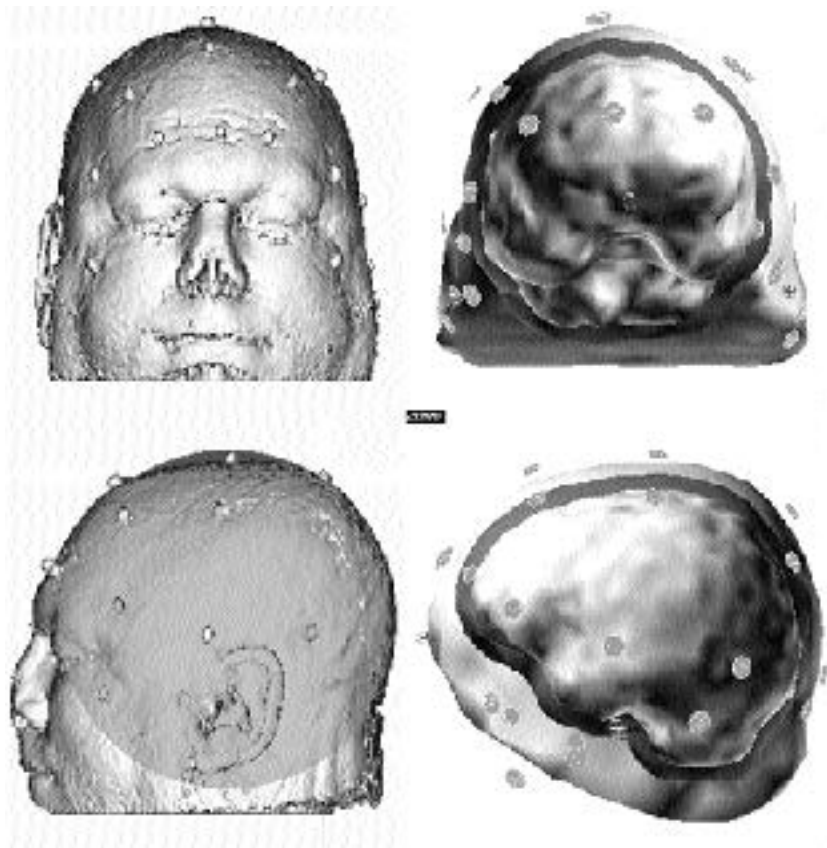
Right: Realistic boundary element method (BEM) head model (inner and outer surfaces of skull and scalp) derived from three-dimensional MRI reconstructions. Left: *Shaded circle* on patient's head depicts the shape of typical spherical head models. Note divergence of the brain and skull base from this spherical shape. (From Ebersole JS. Defining epileptogenic foci: past, present, and future. *J Clin Neurophysiol* 1997;14:470–483, with permission.)
